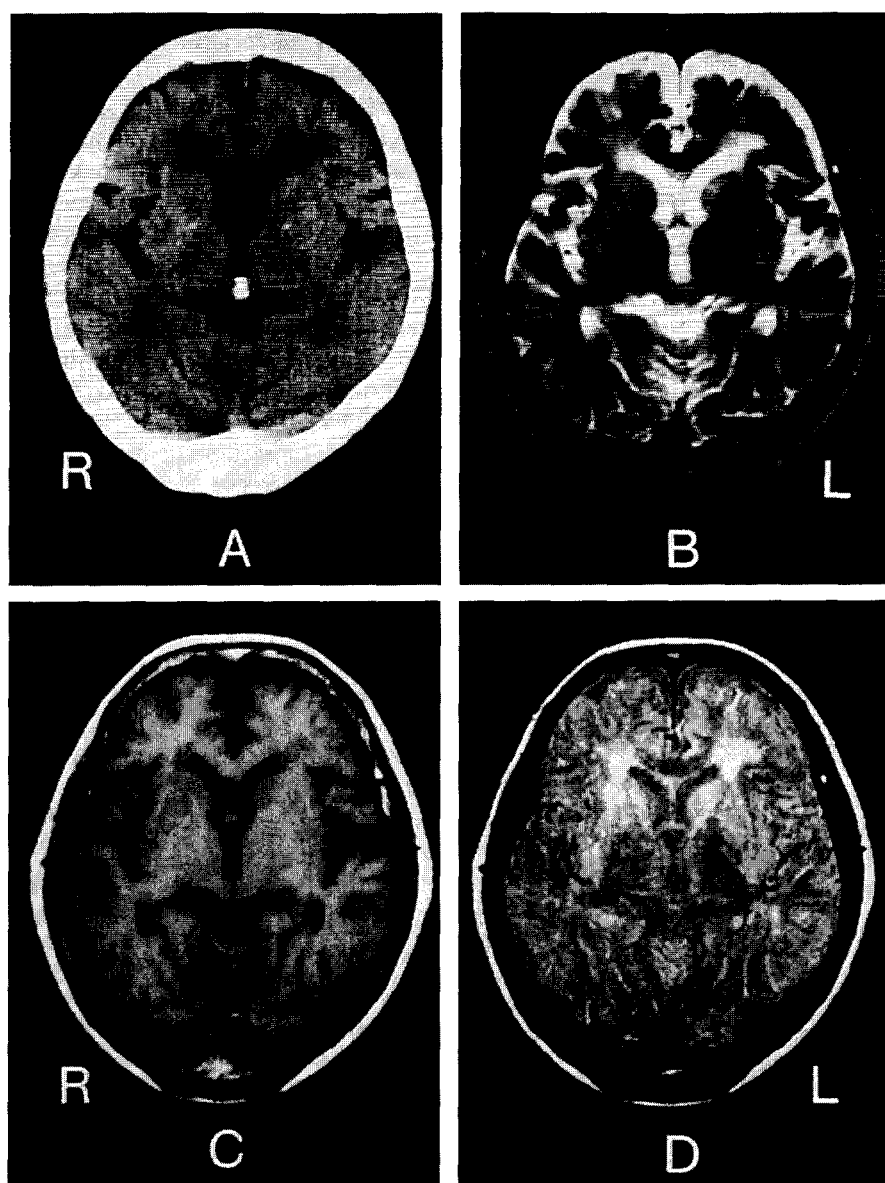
Computed tomography and magnetic resonance imaging in a patient with periventricular lucencies. A: CT. B:  $T_2$ -weighted image. C:  $T_1$ -weighted image. D: proton density image. Mild periventricular lucencies are present.
